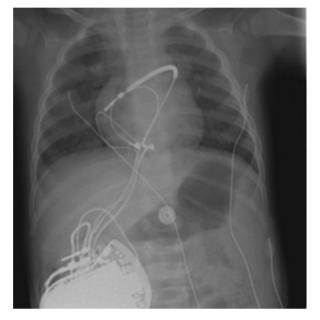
Chest radiography after implantation of an implantable cardioverter defibrillator with an epicardial coil, a bipolar sensing lead, and an abdominal generator.
